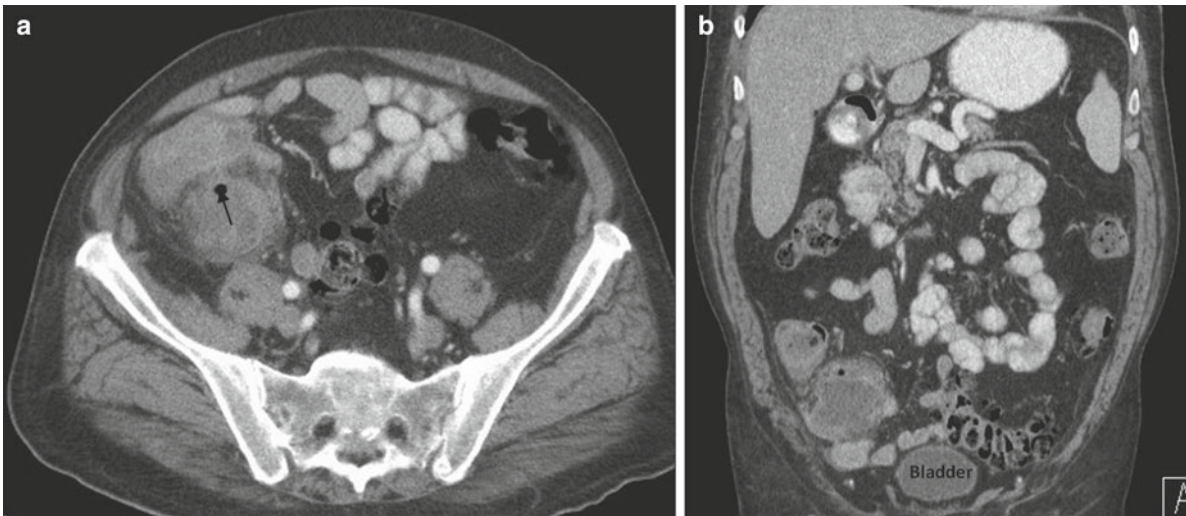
An 89-year-old man presents with fever, nausea, vomiting, and severe RLQ abdominal pain. (a, b) Axial and coronal oral and intravenous contrast enhanced CT images in the lower abdomen
